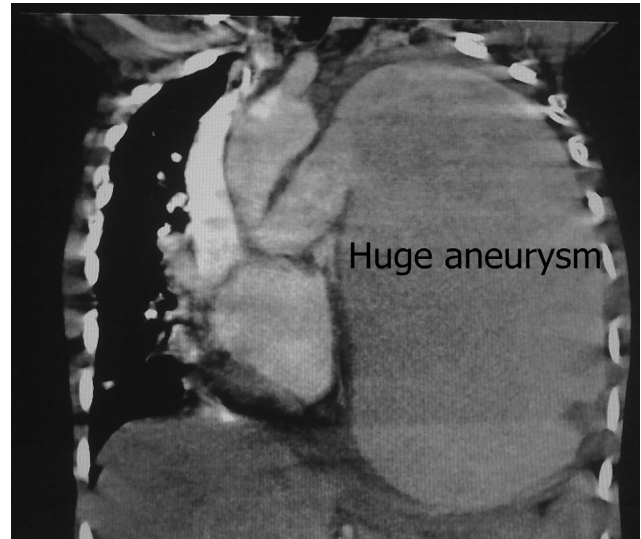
CT angiogram showing huge pulmonary artery aneurysm pushing down the left diaphragm and mediastinal shift to right side. We can see the amount of lung volume with which patient was surviving till now.
